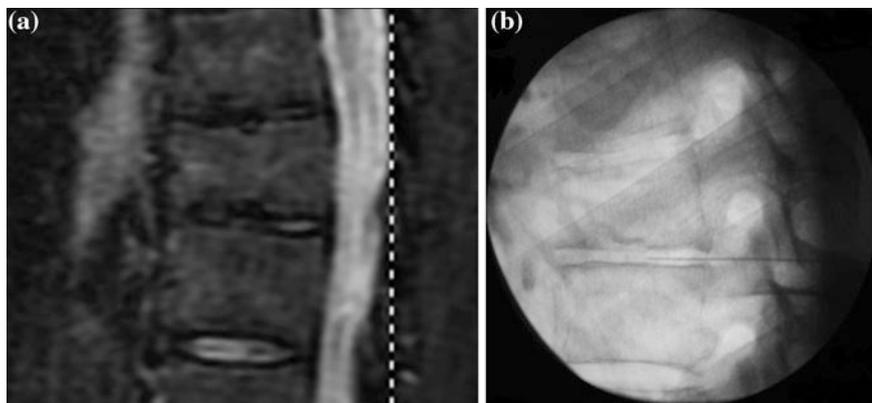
Case #3 a T7-T8 and T8-T9 disc degeneration, T2 MRI. b Needle in position for PRP injection of T8-9
